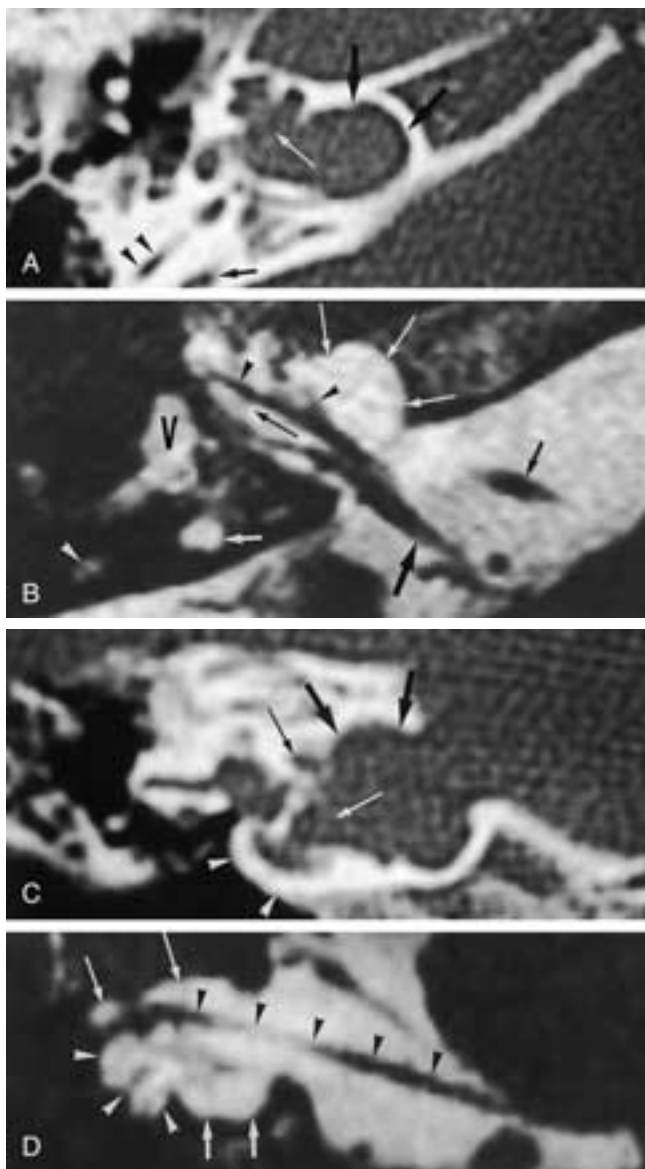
X-linked deafness/gusher ear in a patient with congenital deafness. A, Axial CT image through the right inner ear. There is no bony barrier between the IAC canal and the basal turn of the cochlea (long white arrow), and the modiolus is absent. There is a bulbous enlargement of the IAC (large black arrows), which is another typical finding in patients with X-linked deafness. The diameter of the vestibular aqueduct (small black arrow) is larger than the diameter of the posterior semicircular canal (black arrowheads). Therefore, a large vestibular aqueduct is present. B, Axial T2-weighted gradient-echo image through the right inner ear. The bulbous IAC can again be seen (long white arrows). The bony separation between the fluid inside the IAC and the basal turn of the cochlea is absent (long black arrow), as is the modiolus. Therefore, the cochlear branch of the VCN can be followed from the IAC into the cochlea, and even the separation in some of the distal branches (spiral ganglia) can be seen (black arrowheads). The enlarged endolymphatic duct (small white arrow) can be recognized and has a larger diameter than the posterior semicircular duct (white arrowhead). Normal facial nerve (small black arrow) and VCN (large black arrow) in the right cerebellopontine angle. Vestibule (V). C, Coronal CT image through the right inner ear. The bulbous enlargement of the right IAC can again be seen (large black arrows), and the fluid inside the IAC continues, without any barrier (long white arrow), into the cochlea (white arrowheads). The labyrinthine segment of the facial nerve canal is enlarged (long black arrow). D, Coronal T2-weighted gradient-echo image through the right inner ear. The IAC is wide and has a bulbous shape (small white arrows), and the CSF in the IAC cannot be separated from the fluid inside the cochlea (white arrowheads). The facial nerve can be followed in the cerebellopontine angle and IAC (black arrowheads) and continues in the enlarged labyrinthine segment of the facial nerve canal. Normally, this segment of the facial nerve canal is very small, and there is no space left between the nerve and the walls of the canal. However, in gusher ears the canal enlarges, and fluid can be found between the nerve and the canal walls (long white arrows).
